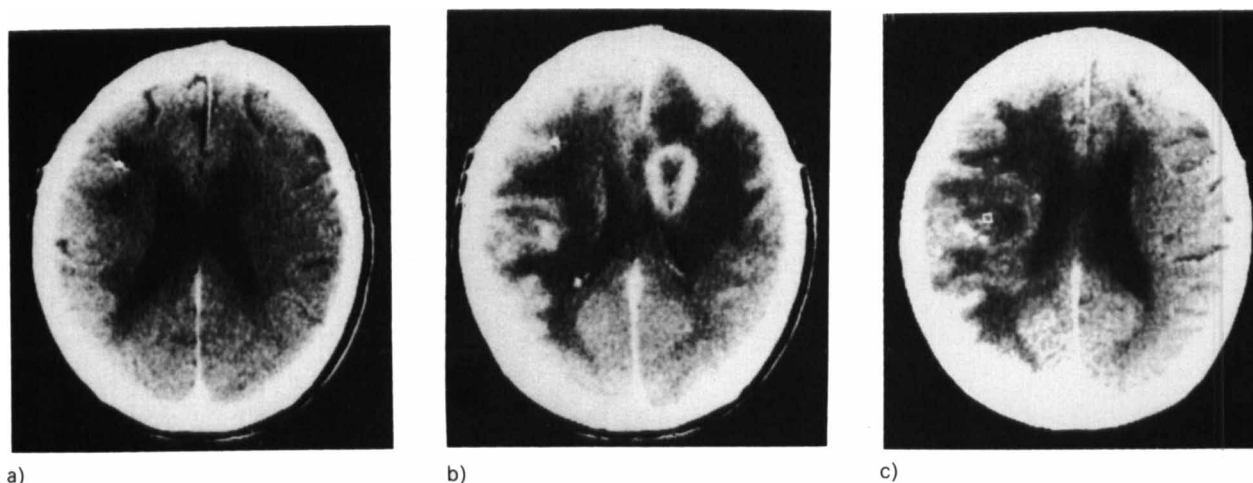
Case No. 1. Patient treated with intraarterial carmustine in right internal carotid artery followed by irradiation. a) CT 6 months after irradiation of the right hemisphere and the medial part of left frontal lobe: Postoperative changes after biopsy with clips on the right side. b) CT 8½ months after irradiation. Marked bilateral oedema and ring-shaped enhancement paraventricularly on left side. c) CT 17 months after irradiation. Reduced oedema. The earlier enhancement is not visible. Small calcifications parietally on right side.
